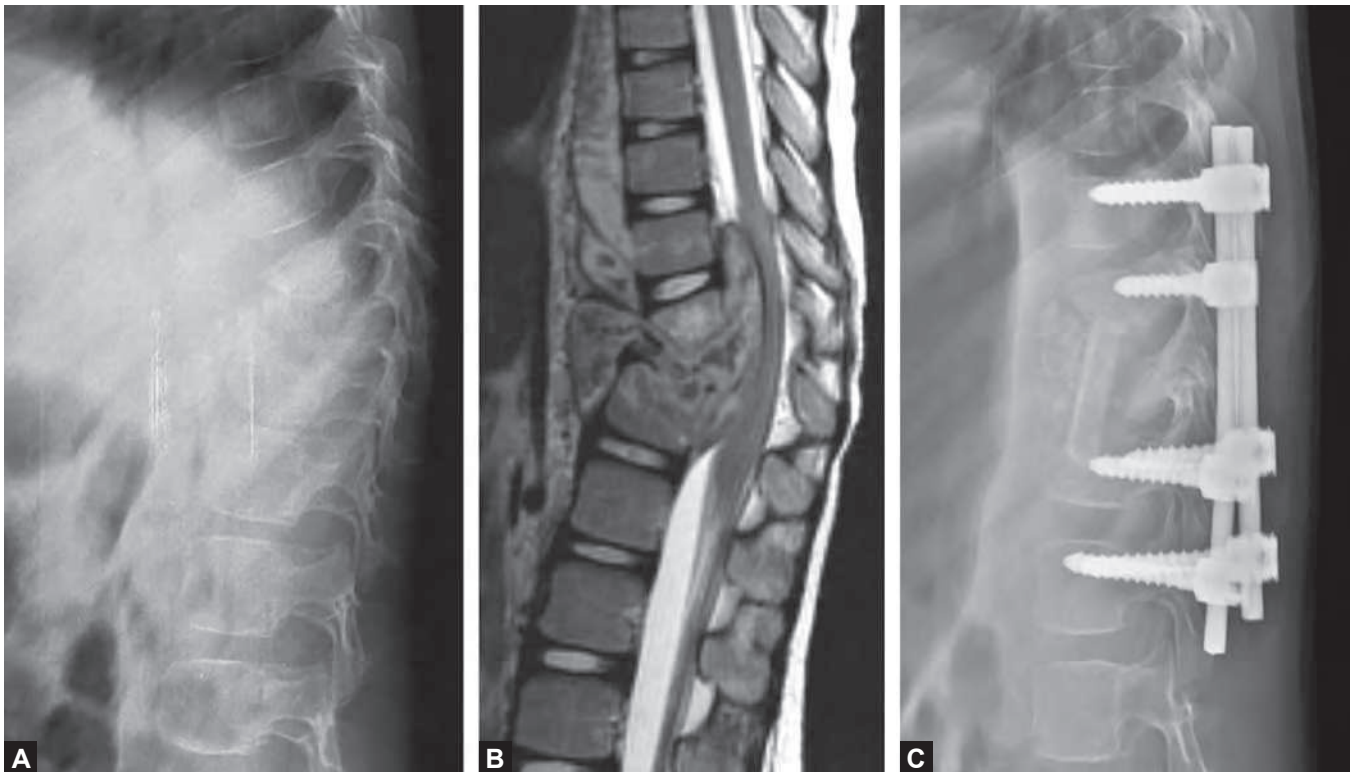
Posterior fixations for the treatment of tuberculosis should include at least two normal vertebral segments above and below the diseased segments. In this patient with T9–11 tuberculosis, four contiguous segments have been stabilized. In the follow-up radiographs, it is noted that the affected vertebra has collapsed leading to local kyphosis and implant pullout at the caudal fixation. The deformity did not progress further and healing occurred with complete resolution of the abscess.
